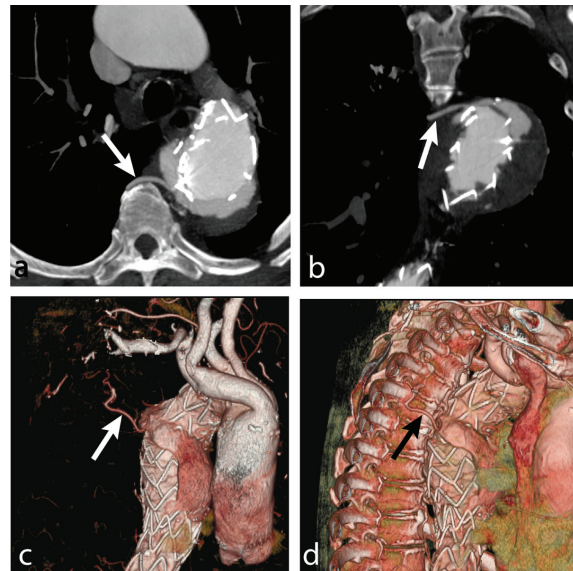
Type II endoleak: axial (a) and coronal CT images (b) of patient with thoracic aneurysm underwent TEVAR demonstrate type II endoleak from adjacent intercostal artery. 3D volume rendering with (c) and without (d) bone removal in oblique view show also retrograde flow into aneurysmal sac
